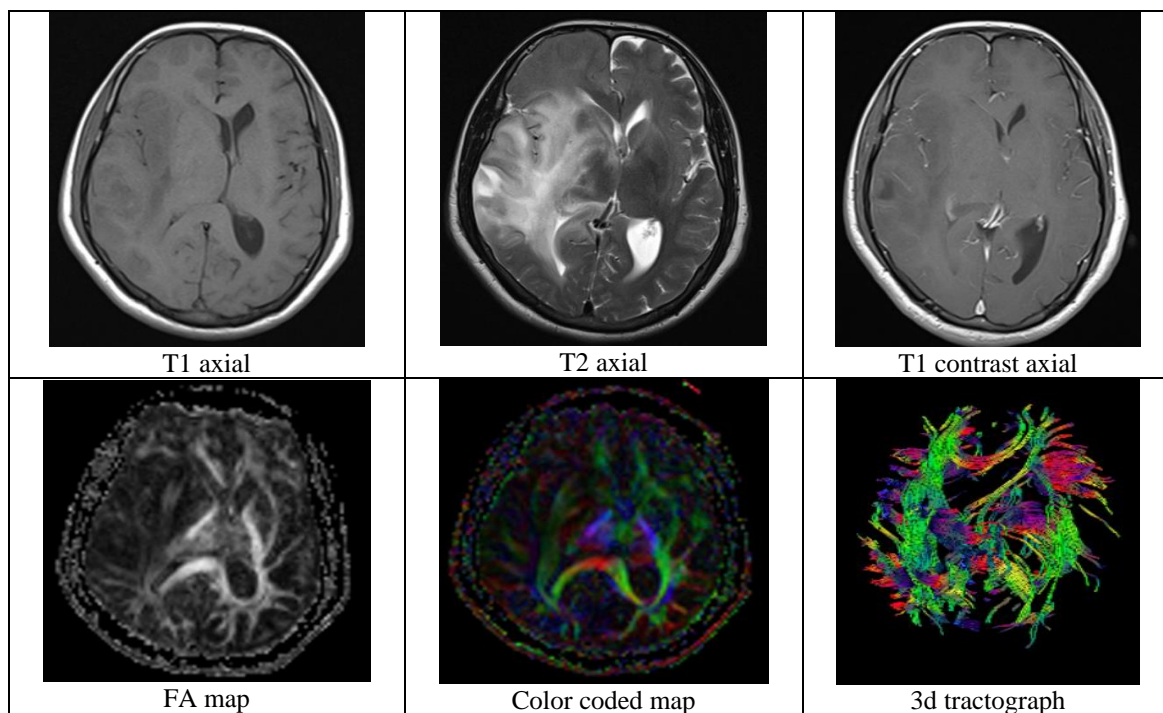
A thirty six year old male patient with complaints of seizures, MRI shows a large T1 hypointense T2 hyperintense lesion in right temporal and parietal lobes with focal irregular contrast enhancement. Findings are s/o low grade glioma. DTI shows decreased FA with infiltration of peritumoral white matter. FA 0.12 ± 0.01 , contralateral normal white matter 0.33 ± 0.05 .
